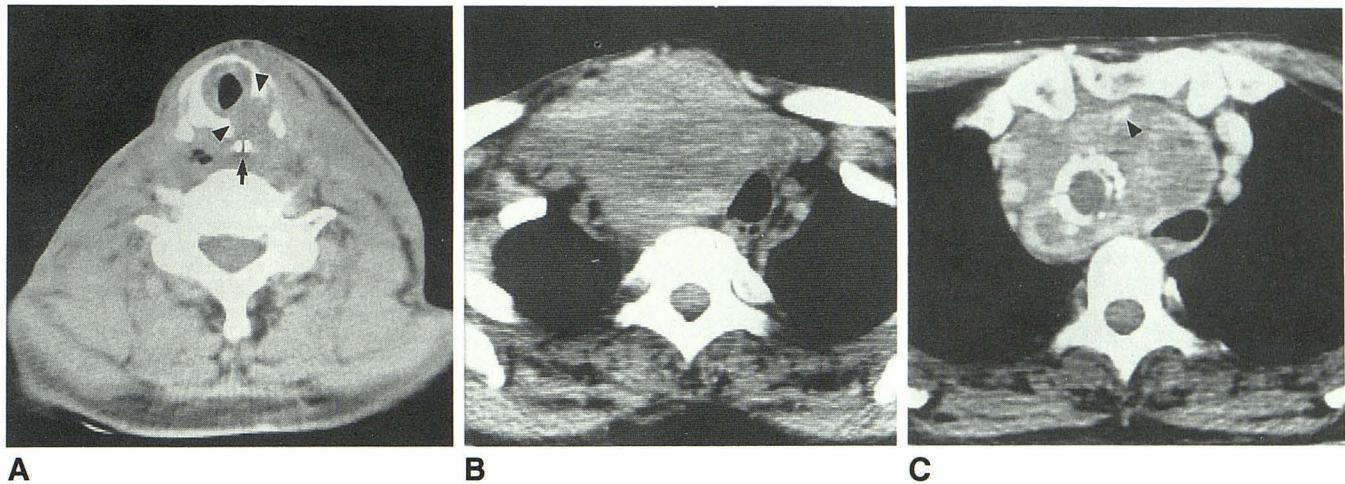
A, Laryngeal invasion in case 13. Laryngeal invasion by tumor was diagnosed by CT, because ossified cricoid cartilage (arrowheads) had been partly destroyed by tumor. Nasogastric tube (arrow) is seen in esophagus, which has been encroached on by tumor. Pathologic studies showed tumor invasion of larynx and esophagus.
